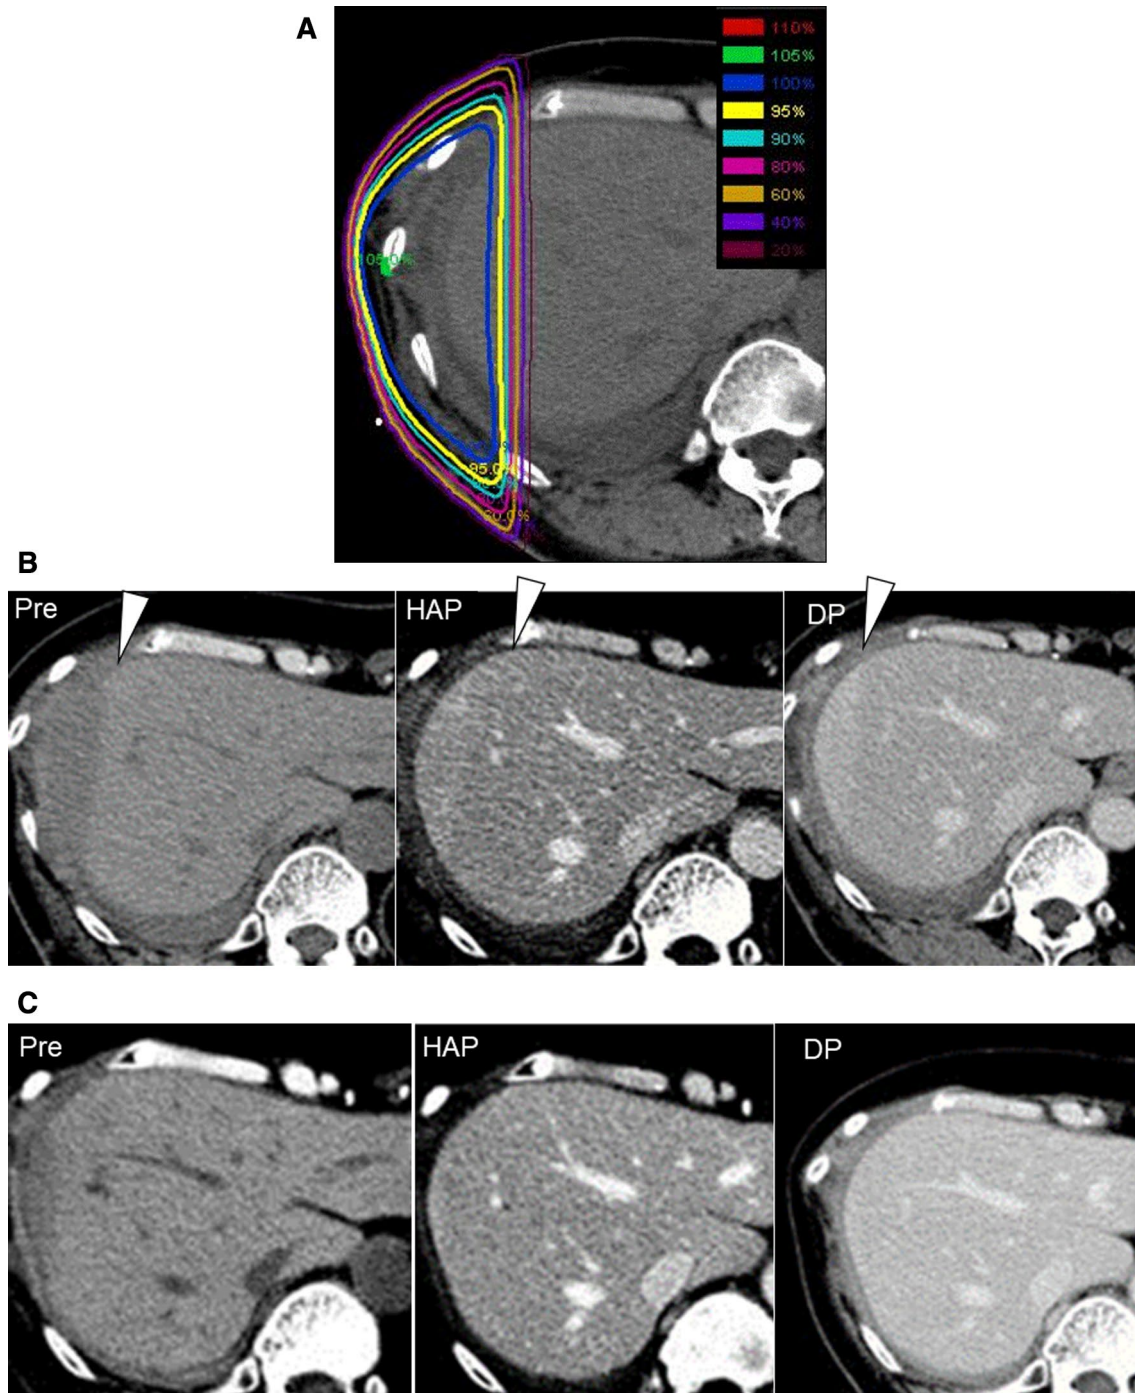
S8 HCC (arrowhead) treated with PBT (76 GyE/20 Fr). During the HAP of dynamic CT before treatment, irradiated surrounding liver tissue exhibited early enhancement caused by congestive changes in the sinusoids after liver irradiation during the acute phase
